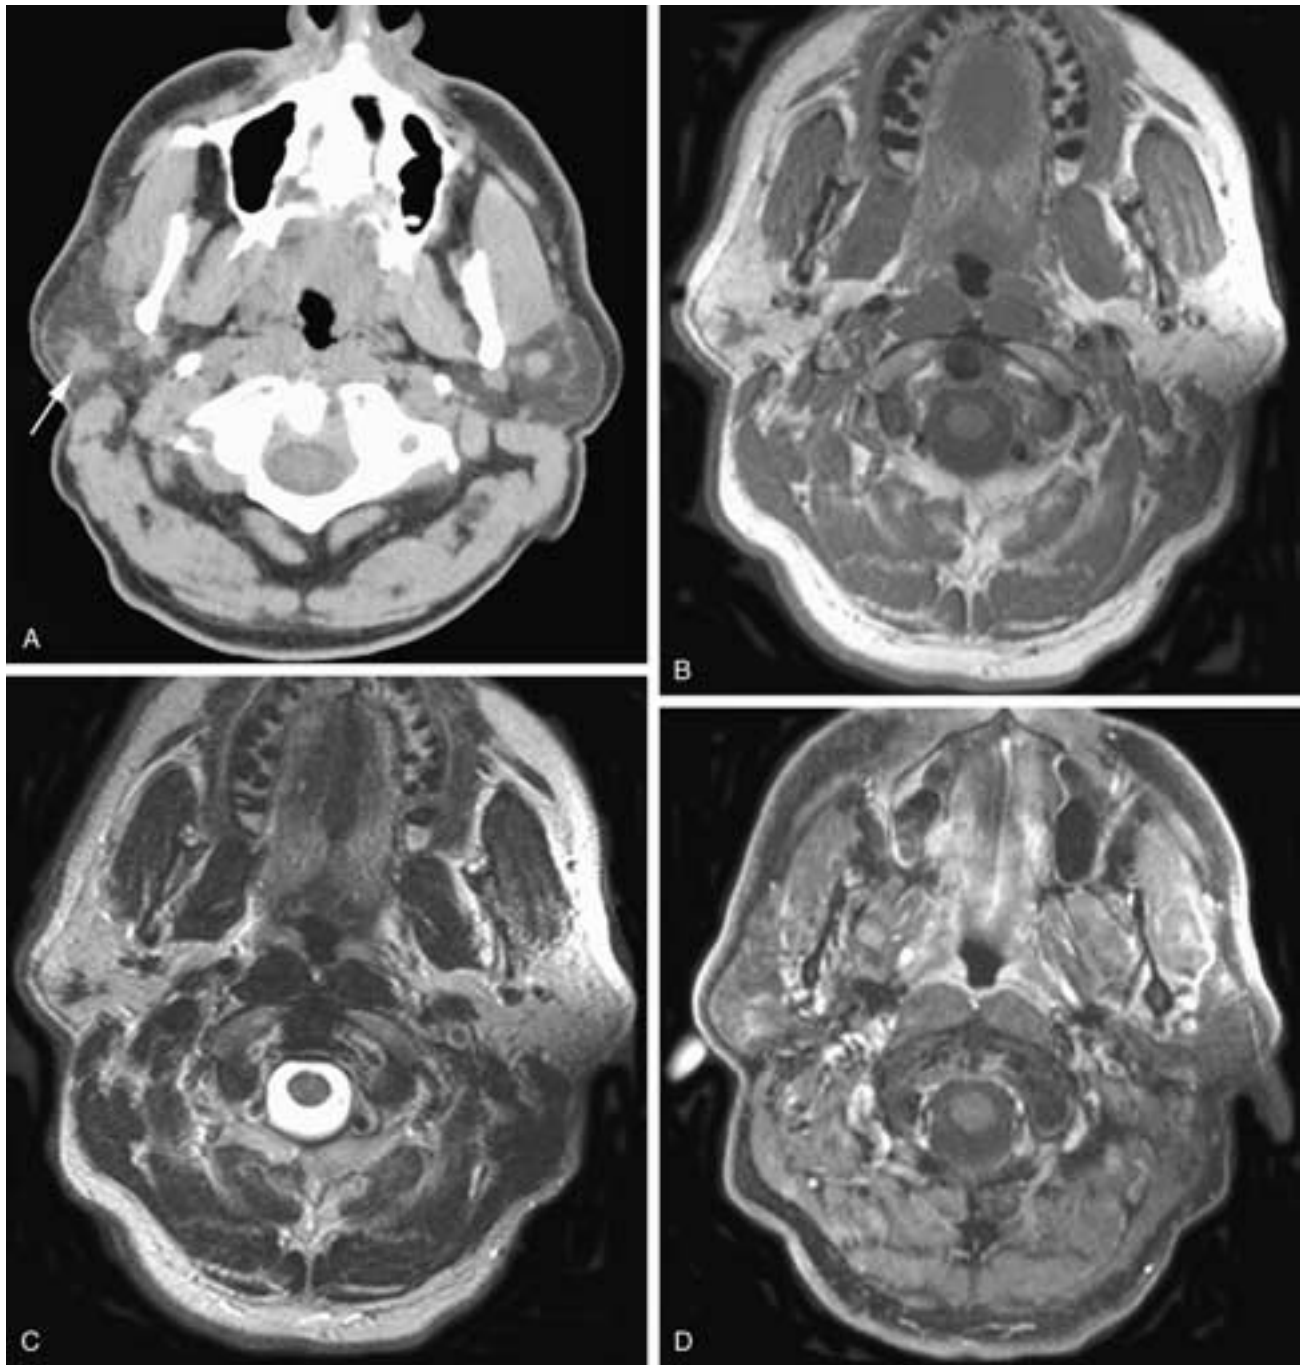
Axial CT scan (A) shows an irregular soft-tissue mass in the right parotid gland (*arrow*). Axial T1-weighted (B), T2-weighted (C), and T1-weighted, fat-suppressed, contrast-enhanced (D) MR images show the mass to have low signal intensity on the T1- and T2-weighted images and to enhance. This was a scar at the site of a biopsy performed many years prior to this study.
